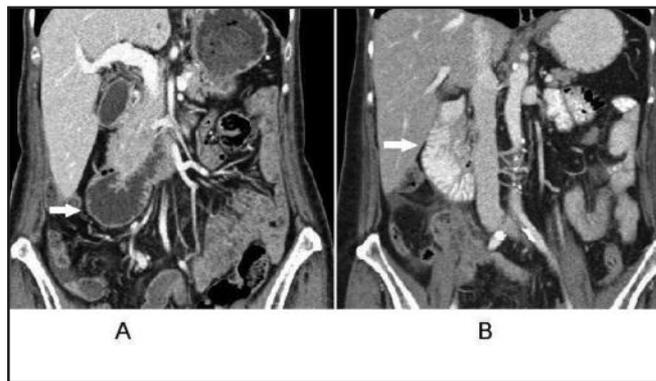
Selected coronal CT images of a 65-year-old female patient with water (A) and gastrografin (B) as OC show comparable bowel wall delineation in the duodenum (arrows) with either OC agent.
